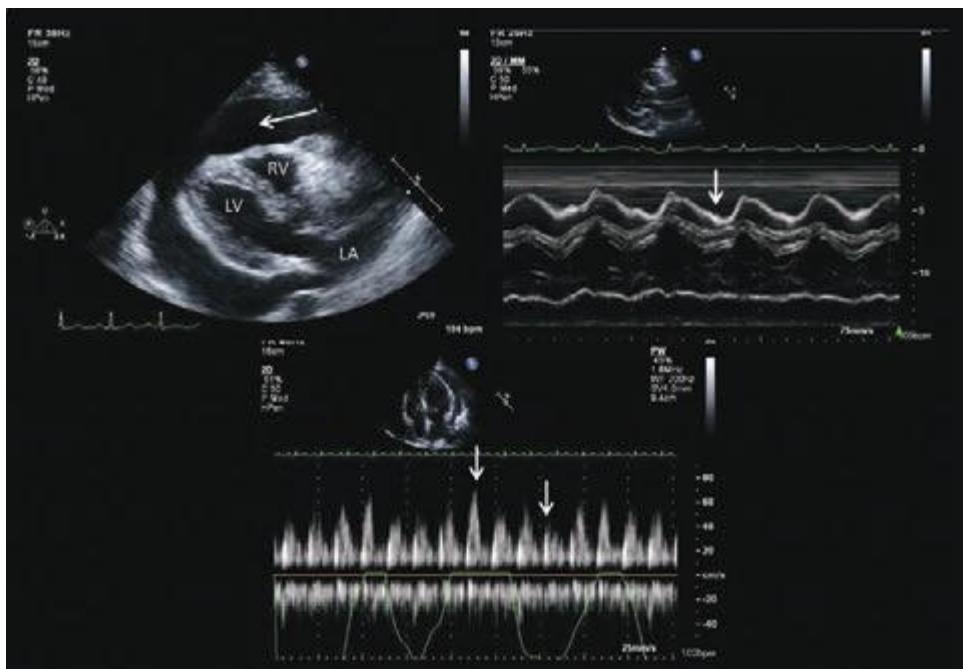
18 A 46-year-old patient with malignant melanoma who presents with acute shortness of breath. Echocardiogram reveals a large pericardial effusion (arrow, upper left) with evidence of cardiac tamponade. M-mode echocardiography (upper right) shows evidence of collapse of the right ventricular free wall during diastole (arrow). Doppler echocardiography (lower panel) shows evidence of respiratory flow variation, consistent with a pulsus paradoxus. LA, left atrium; LV, left ventricle; RV, right ventricle. (See Video 271e-17.)
